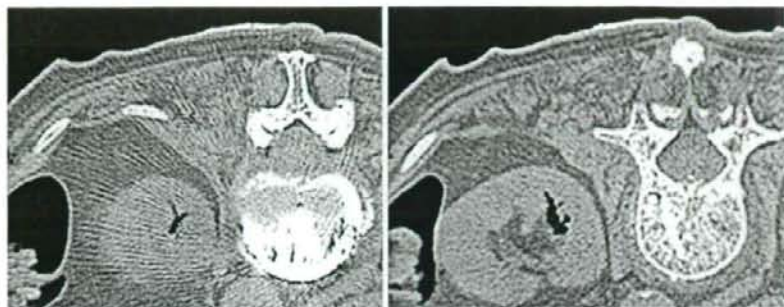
CT images following carbon dioxide intraosseous venography in the prone position
